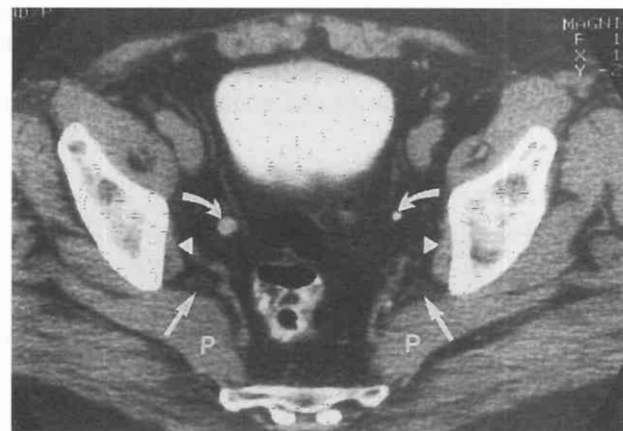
Normal anatomy. CT scan through the sciatic notch shows the sciatic nerves (straight arrows) anterior to the piriformis muscles (P) and the obturator internus muscles (arrowheads) along the pelvic sidewalls. The pelvic ureters (curved arrows) are immediately posterolateral to the pelvic peritoneal reflections.
